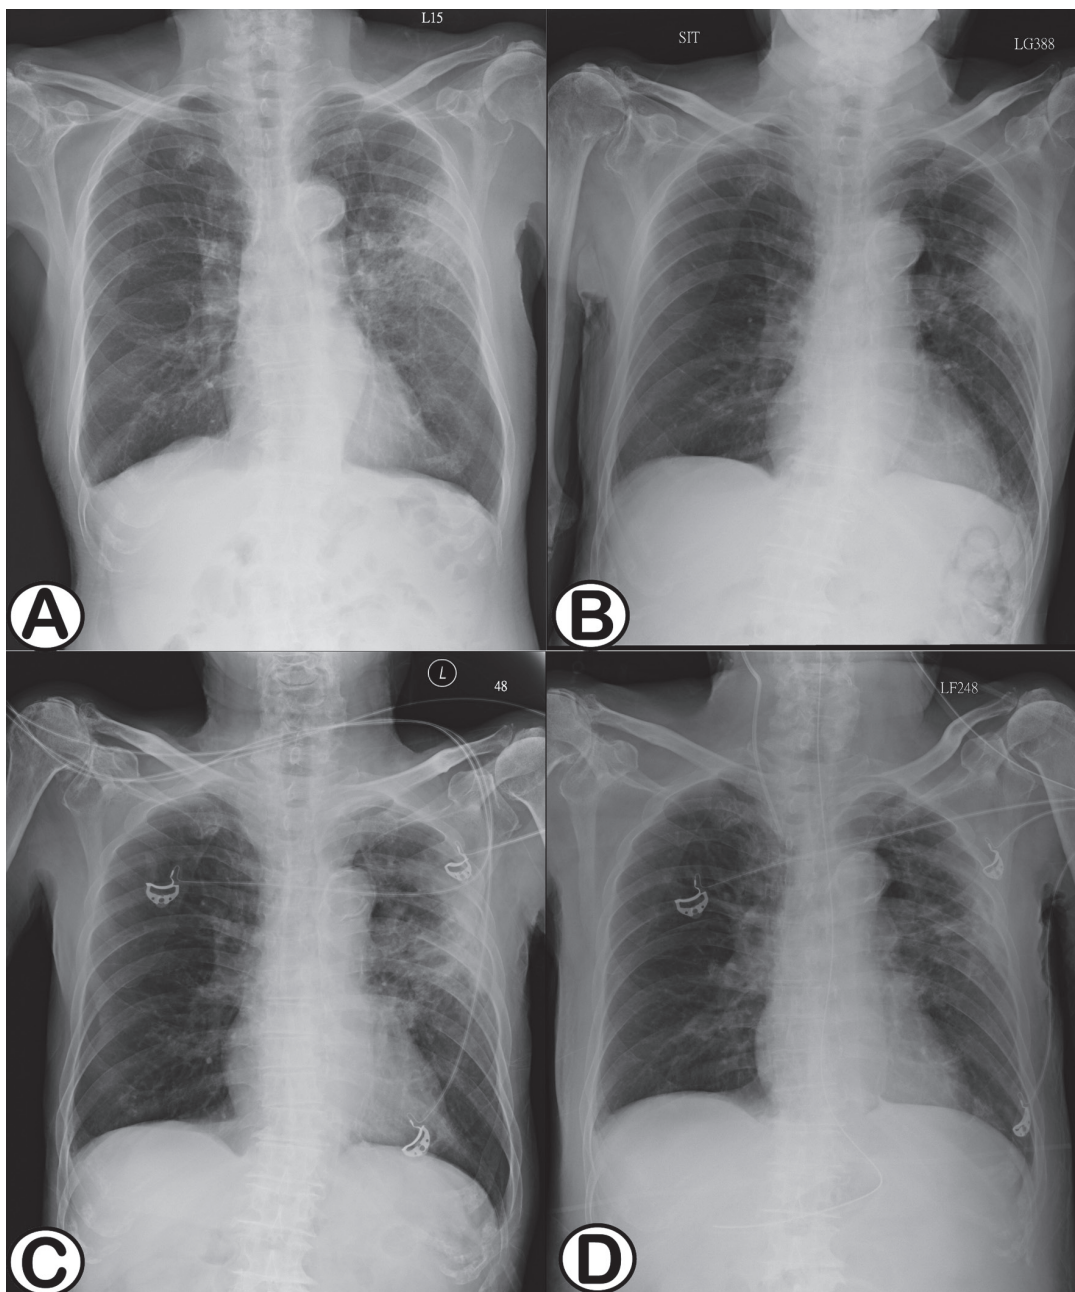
Chest radiographs on (A) Day 0, first hospital visit with patchy opacity at the LUL field, (B) Day 23, delayed radiographic resolution of the patchy opacity in the LUL field, (C) Day 148, the last hospital visit due to altered mental status, showing persistence of the LUL patch, (D) Day 167, significant regression of the LUL patch after treatment with trimethoprim-sulfamethoxazole plus meropenem for 2 weeks. LUL: left upper lung.
